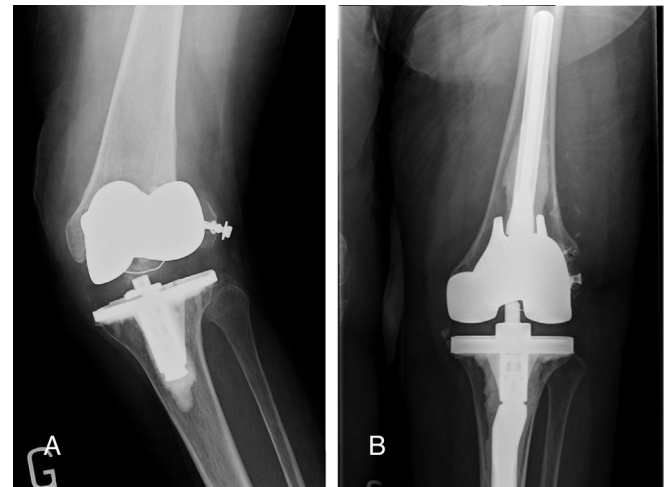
A 65-year-old woman who had an intraoperative TKA periprosthetic lateral femoral condyle fracture treated with ORIF and a postoperative brace that failed. She underwent a TKA revision with use of a femoral cone, on which was fixed the lateral epicondyle with a washer and screw. (A) Preoperative AP radiograph. (B) Postoperative AP radiograph at the latest follow-up.
